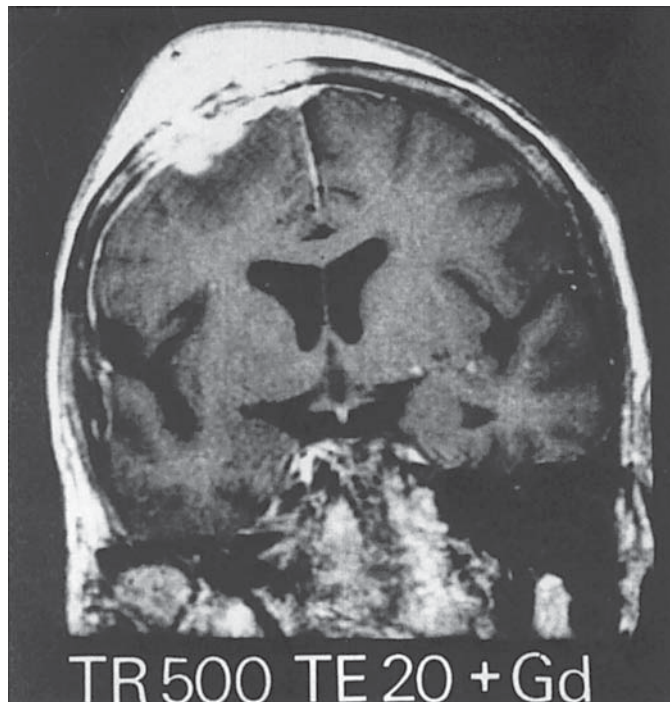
Enhanced MRI scan of head in 62-yr-old man whose NHL presented as an enlarging skull mass followed by focal seizures.
